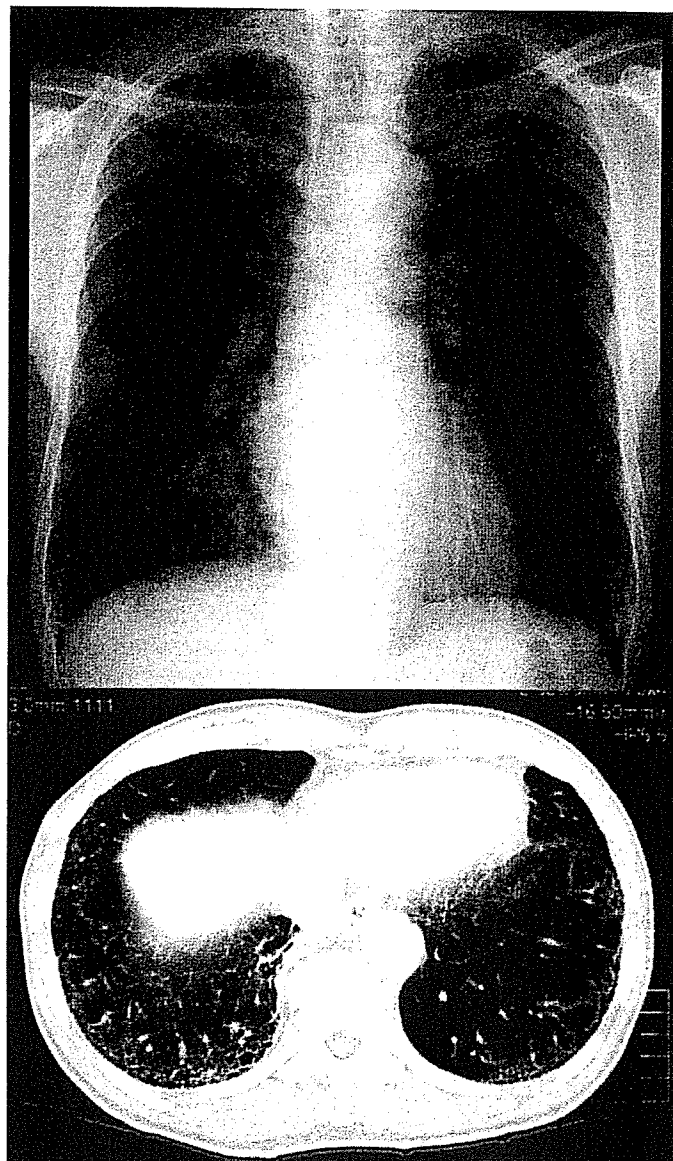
Mild interstitial shadow. An X-ray film of the chest shows no obvious interstitial shadow. A CT film of the chest demonstrated ground-glass opacity in the right basal lung. Interstitial shadow is classified as mild in this case.
